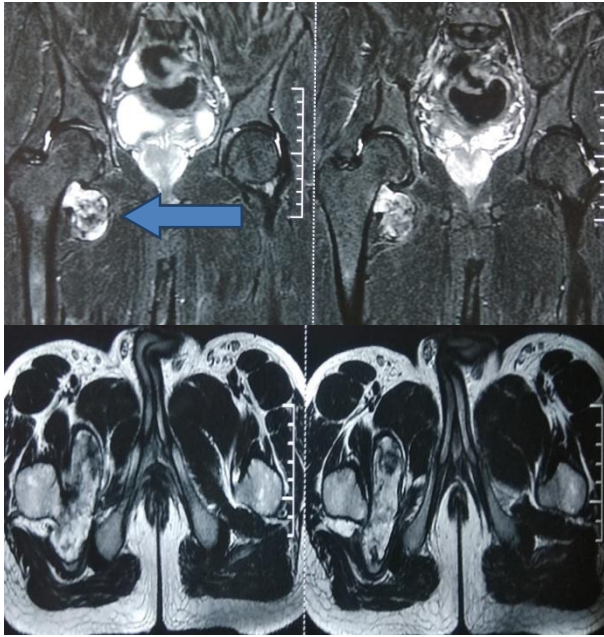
MRI showing of the extent of local spread in anterior, posterior and medial direction with a covering cartilage cap, STIR images (arrow).
